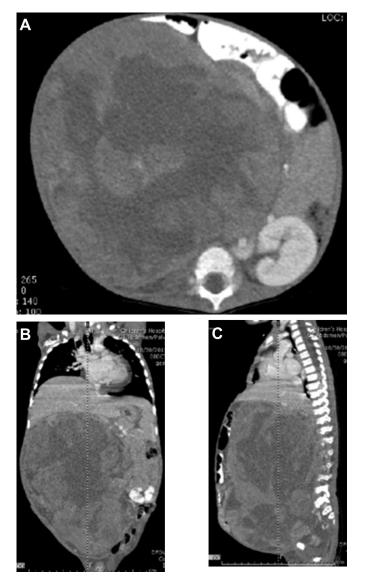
Computed tomography of the abdomen demonstrating a large heterogeneous mass with mass effect, ascites, and possible invasion of the inferior vena cava. A, B, and C demonstrate displacement of the abdominal viscera in the axial, coronal and sagittal planes respectively.
